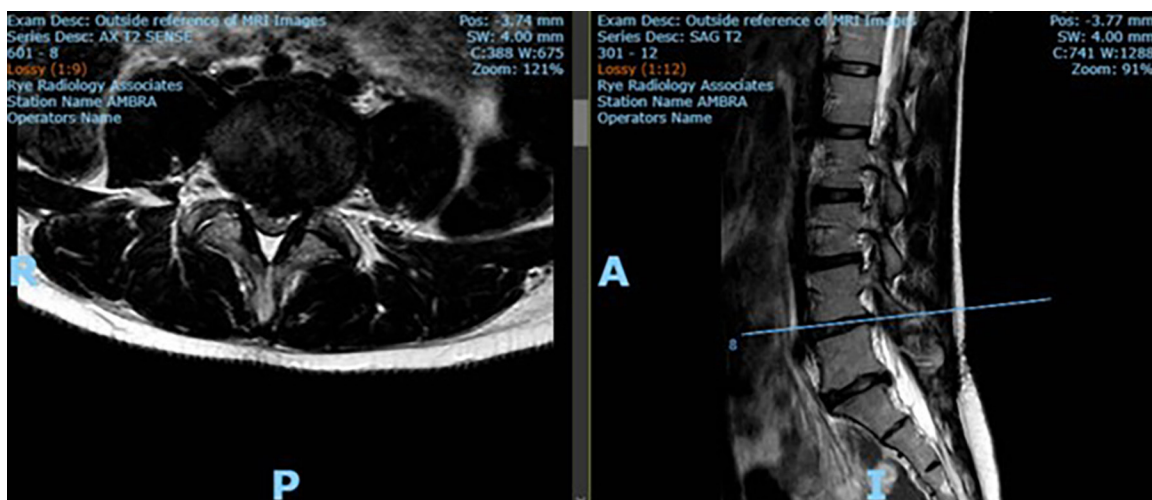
Lumbar MRI from October 2023.
